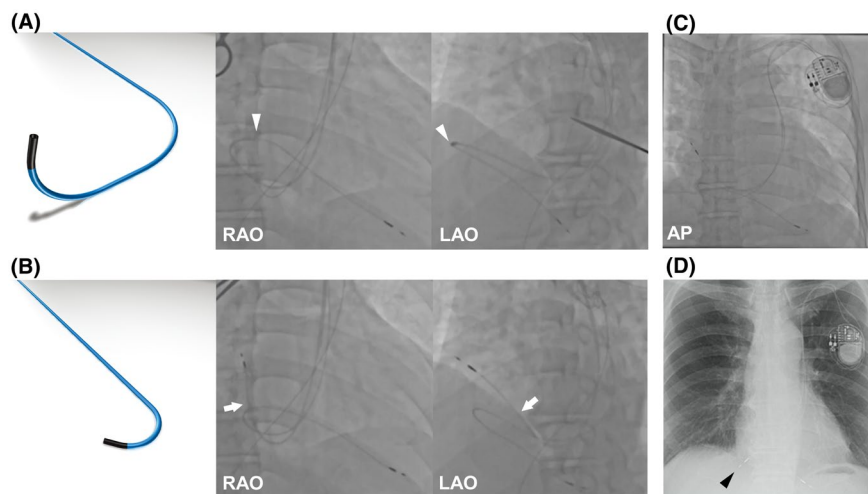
A, Model C315-S10 (left) and the tip of Model C315-S10 (white arrowhead) in the fixation of the right ventricle pacing lead in the right anterior oblique (RAO) view (middle) and left anterior oblique (LAO) view (right). Model C315-S10 formed a loop in the right atrium. B, Model C315-J (left) and the tip of Model C315-J (white arrow) in the fixation of the right atrium pacing lead in RAO view (middle) and LAO view (right). C, Chest X-ray at the end of the initial procedure. D, Chest X-ray on the seventh day after pacemaker implantation. The black arrowhead represents the tip of the dislodged right atrium lead. The photos of Model C315-S10 and Model C315-J were reproduced with permission from Medtronic Inc. AP, anterior-posterior
